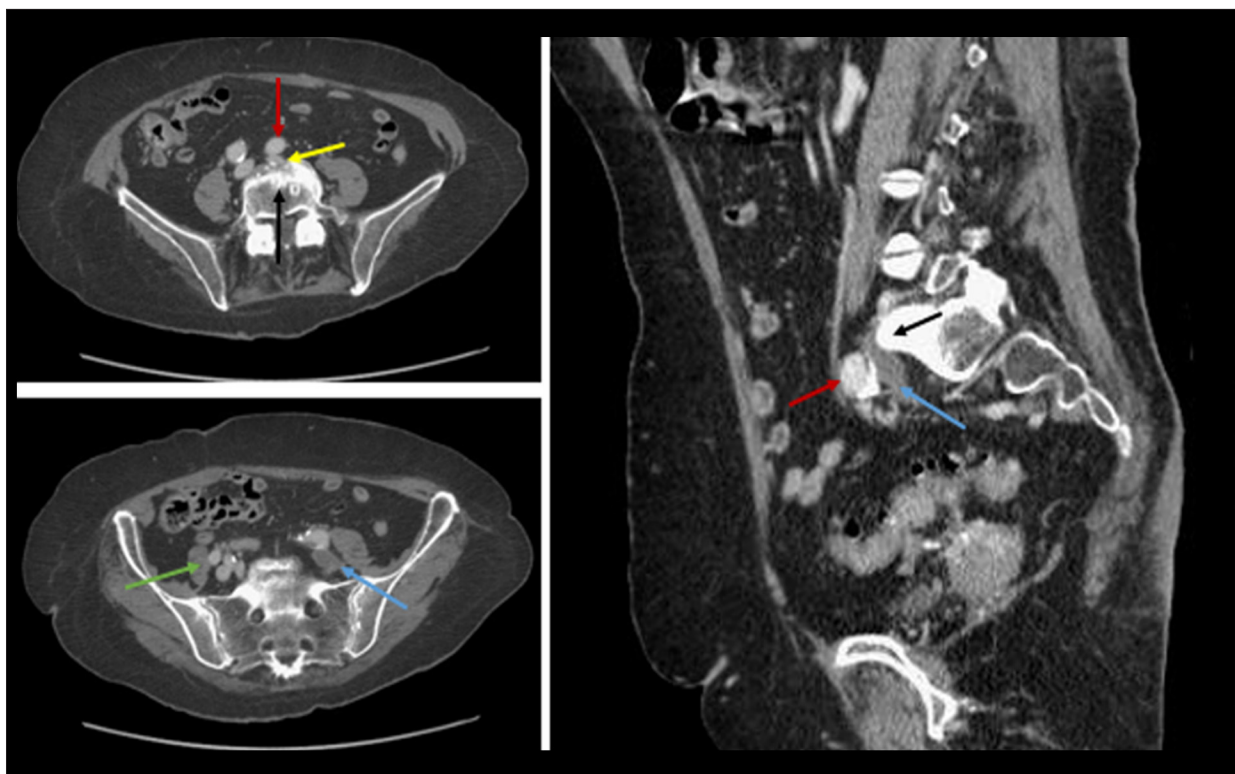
Axial and sagittal pelvic computed tomography venography (CTV) demonstrated left common iliac venous outflow obstruction caused by extrinsic compression of the origin of the left iliac vein (yellow arrow) by the overlying atherosclerotic calcified right common iliac artery (red arrows) crossing against the prominent lumbosacral promontory (black arrow), with resulting thrombosis along the distal left common iliac vein (blue arrows) when compared to patent right common iliac vein (green arrow).
